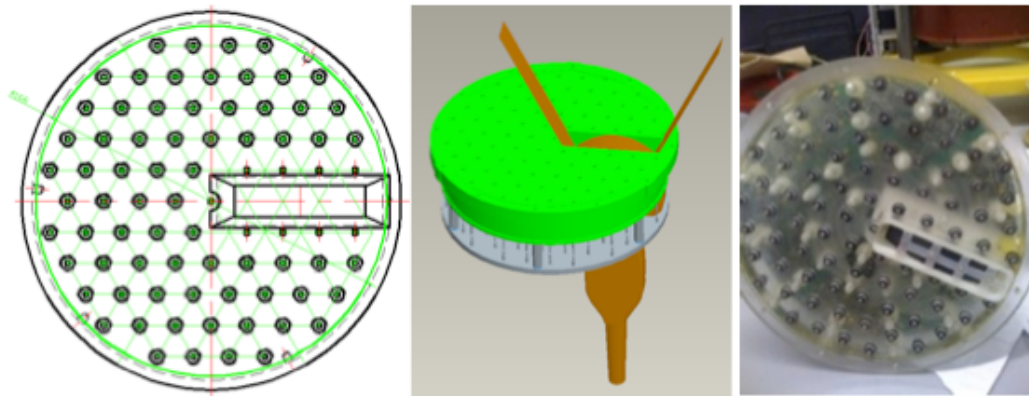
Breast plate with aperture ready for the ultrasound transducer (left); CAD of the plate assembly (middle); Assembled plate with electronics, electrodes, ultrasound and electrode bridge above it (right).
